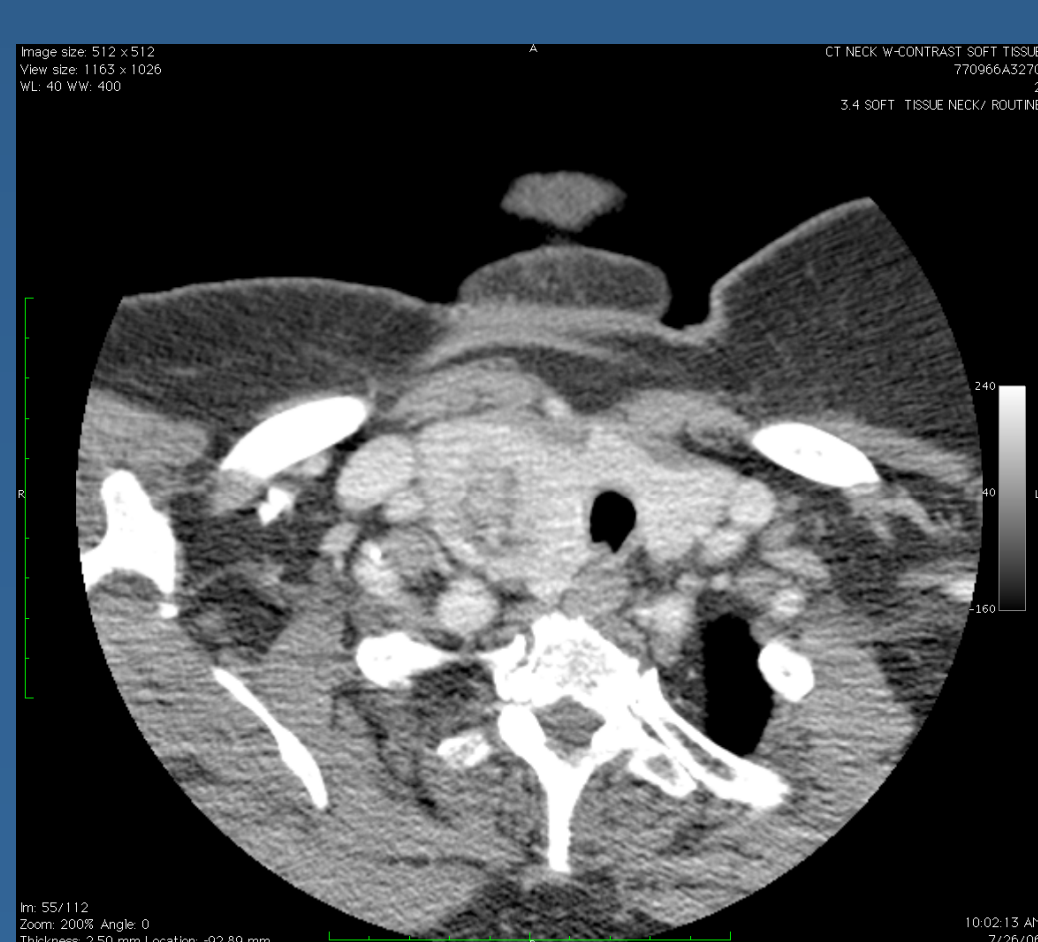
Preoperative CT scan axial image of patient 2, moderate tracheal compression (Preop AHI 39 → Postop AHI 8).
